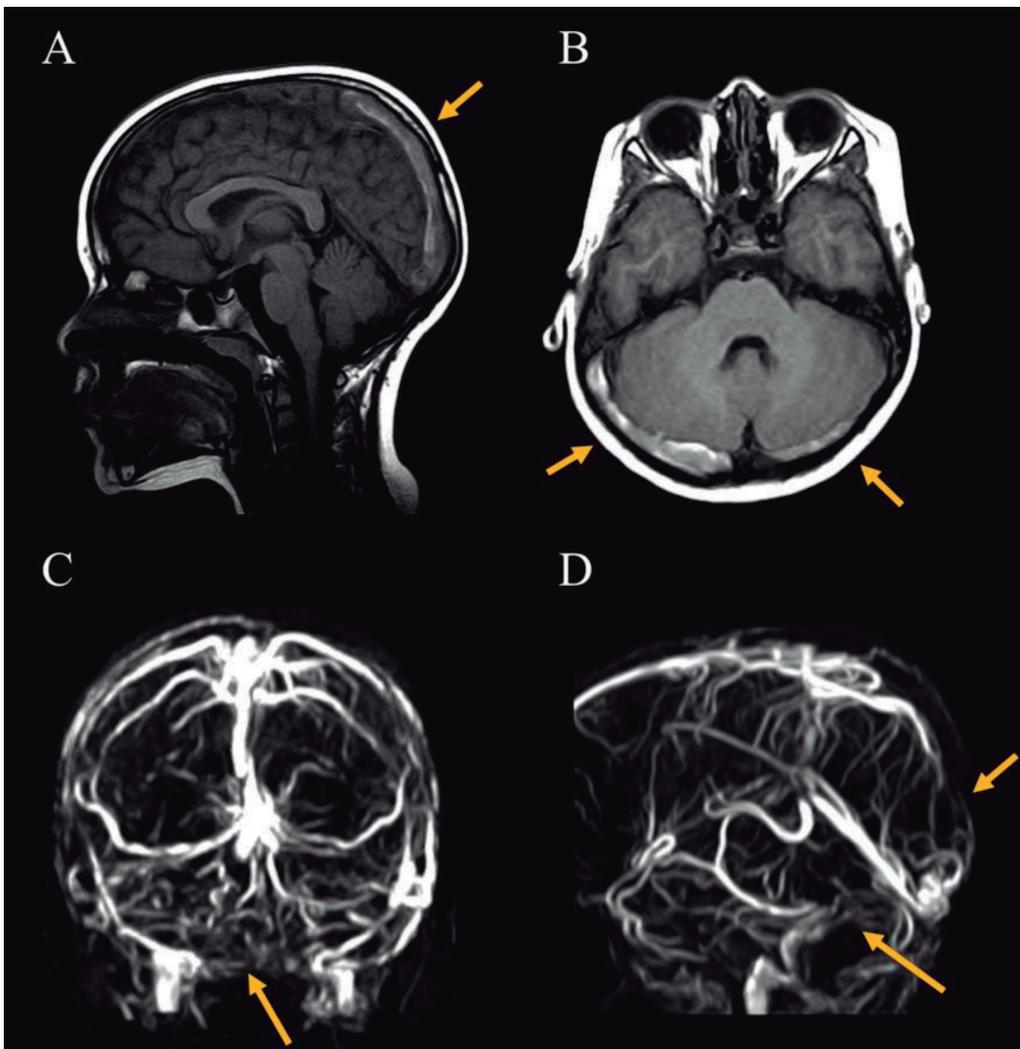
IMRI of the brain of a six-year-old patient with bilateral mastoiditis. Lateral sagittal and axial gadolinium-enhanced T1-weighted images show signs of thrombosis of the distal third of the superior sagittal sinus (A) and both transverse sinuses (B). MRV show signs of thrombosis of the distal third of the superior sagittal sinus, both transverse sinuses (C and D, arrow above), and right sigmoid sinus (D, down arrow).
